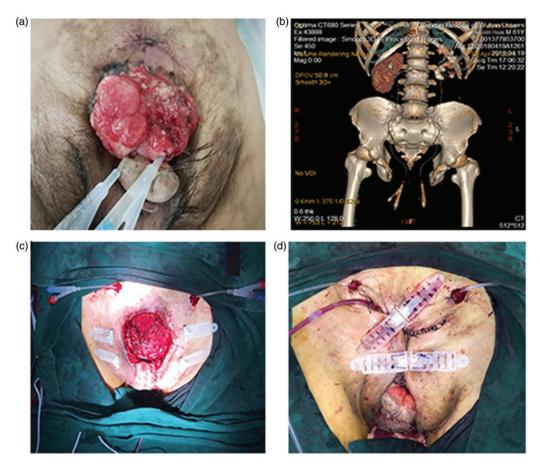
(a and b) Pre-surgical photograph of a patient with bladder exstrophy and the computed tomography-based three-dimensional reconstruction of the pelvis. The width of the pubic gap was 10.1 cm. (c) Intraoperative view of the abdominal skin defect (approximately 9×10 cm). (d) Immediate, direct primary closure was achieved by TopClosure[®] TRS.
